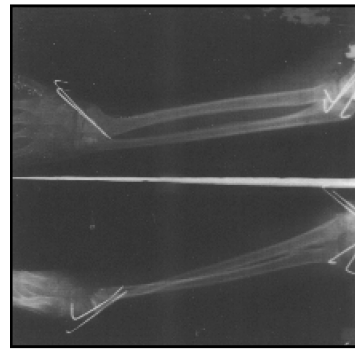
Post-op X-ray showing percutaneous K wire fixation of both fractures
